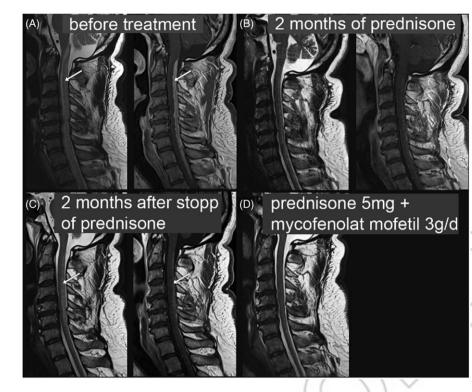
Spinal cord neurosarcoidosis treatment response to prednisone and mycophenolate mofetil. T2-weighted (left) and T1weighted post-contrast images (right) of the cervical spinal cord in a 51-year-old patient with neurosarcoidosis and a tetraparesis below cervical C3 level. A: Before treatment. Arrows point to T2 hyperintensity and T1 contrast enhancement in cervical spinal cord, spreading over multiple cervical segments. B: Dramatic improvement after pulsed steroid treatment slowly tapered off. C: Relapse with clinical and imaging correlate (arrows) 2 months after complete discontinuation of prednisone. D: Clinical and imaging findings are improved under mycophenolate mofetil 3 g/d + 5 mg prednisone (no T1 post-contrast image available at that time point). Courtesy of Dr A. Rosskopf, Balgrist.
